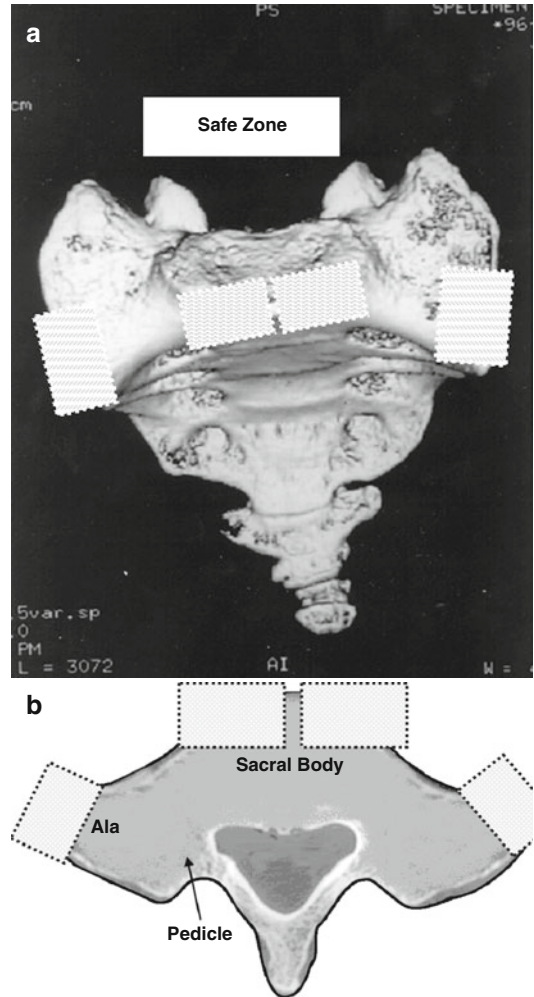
Two safe zones identified on the sacrum for screw placements. (a) Viewed from CT reconstructed 3-D model. (b) Top view of the safe zones on the sacrum
